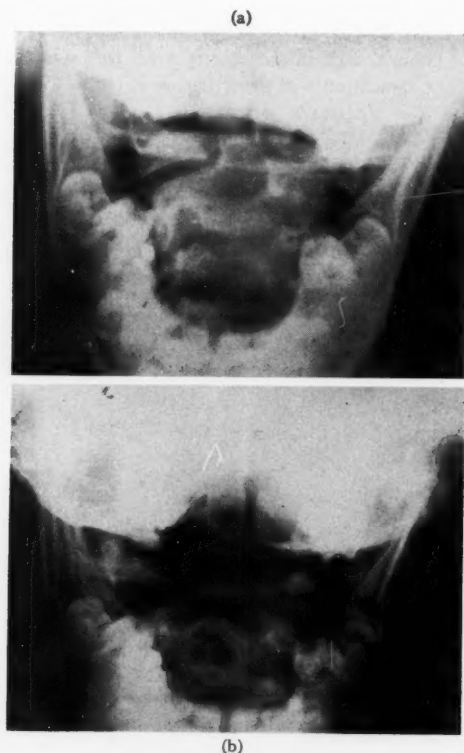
(a) Roentgenogram taken through open mouth. Note asymmetry of transverse process of atlas and left lateral mass of atlas dislocated anteriorly and downward. (b) Roentgenogram after 4 days of head traction.
